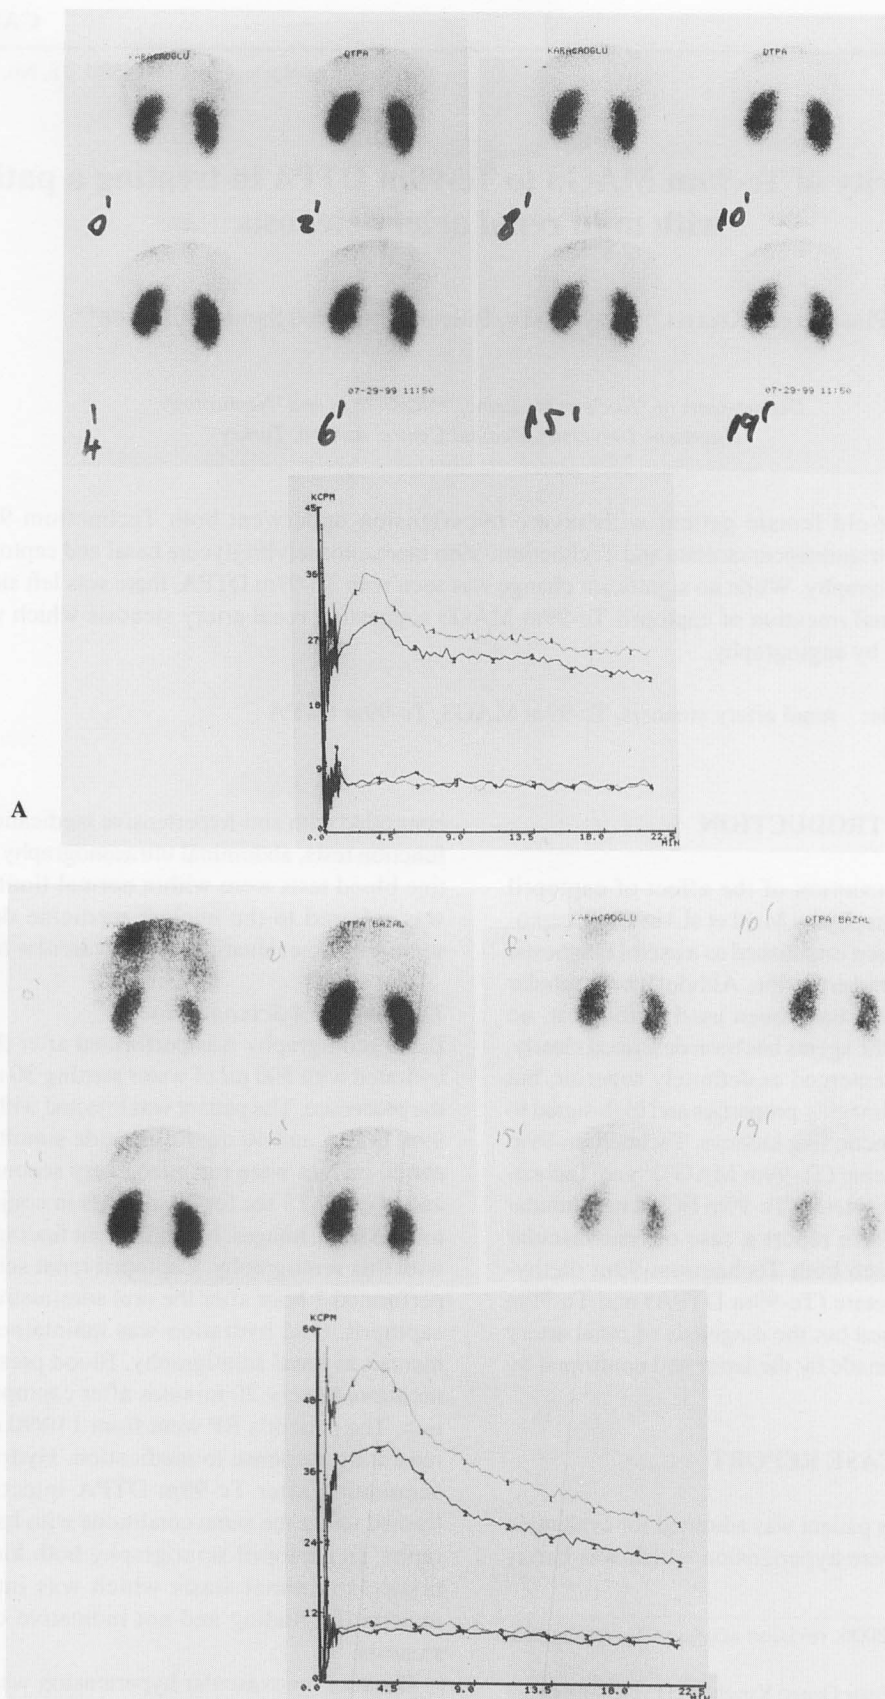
No finding indicating renal artery stenosis was observed on captopril scintigraphy (A). The bilateral cortical retention was thought to be due to the significant hypotension following captopril administration. Basal Tc-99m DTPA scintigraphy (B) was normal.
